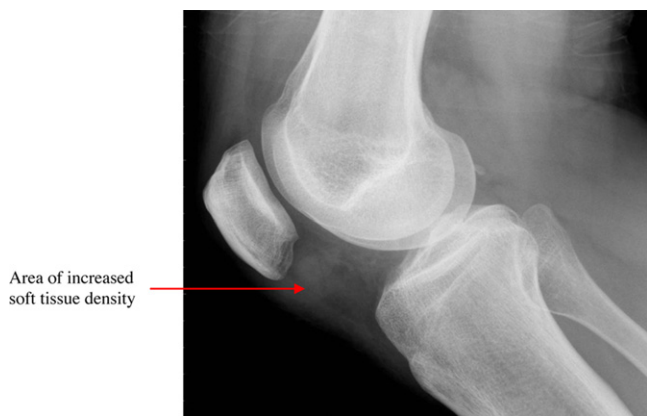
Right knee radiograph – lateral view.
